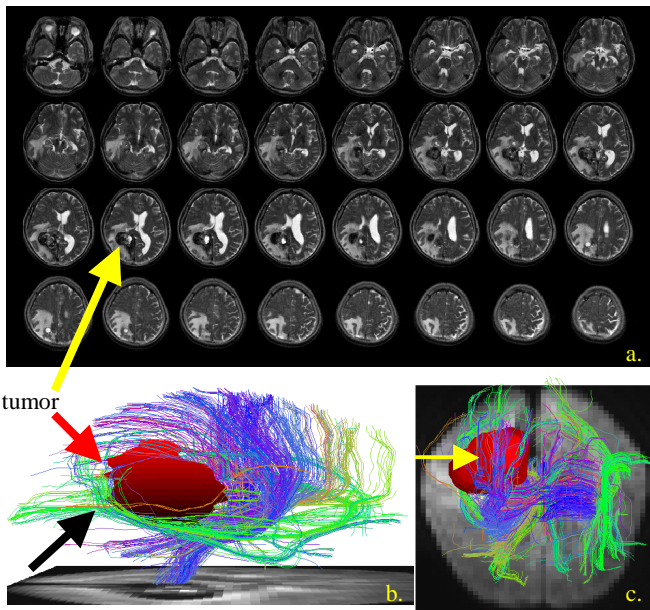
a) T2-weighted images show a tumor in the right occipital lobe (yellow arrow). b) Tractography viewing from the tumor side. The tumor (red arrow) displaces the inferior longitudinal fasciculus downward (black arrow) and corona radiate anteriorly. c) Tractography viewing from the top. Callosal fibers in the splenium are displaced upward (yellow arrow).
